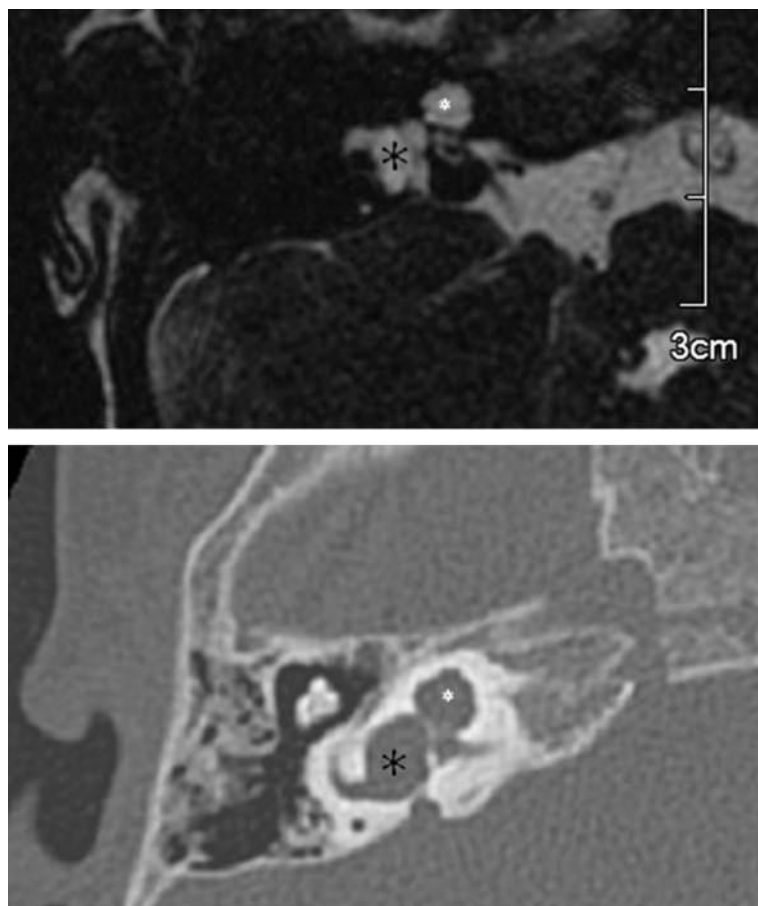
CT and MRI temporal bone, 3-D MR images; bulbous dilatation of the fundi of the internal auditory canals and congenital stenosis of superior semicircular canals.
